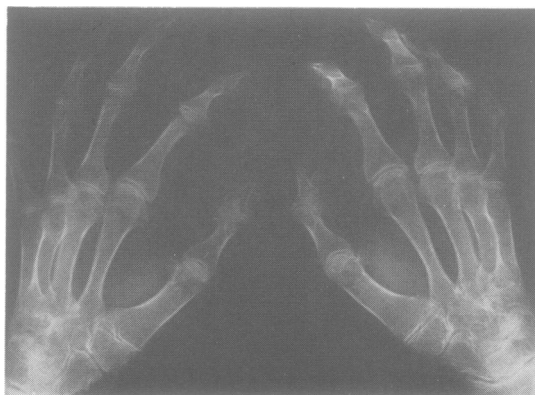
Radiograph of the hands.
